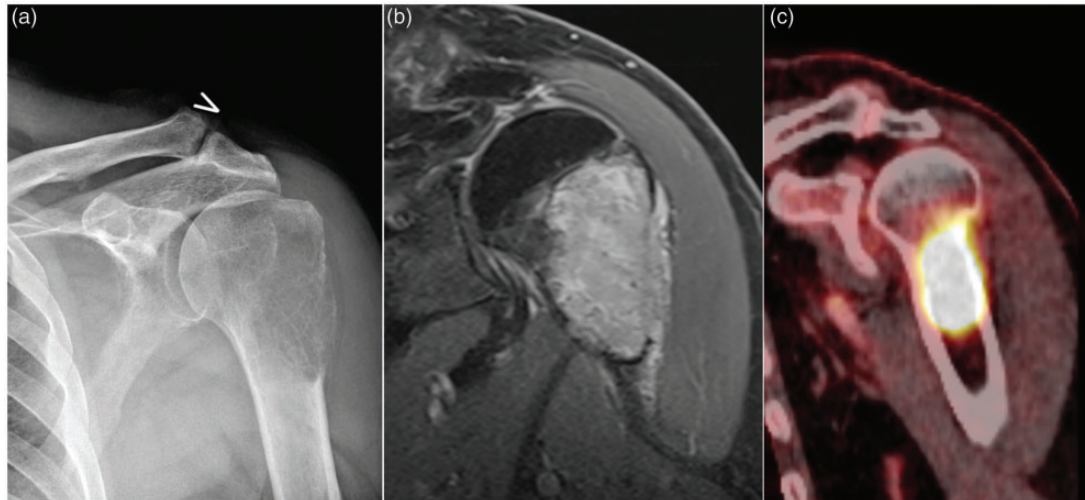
(a) X-ray examination of the left shoulder in frontal projection. (b) MRI of the left shoulder in the coronal view (T1-weighted fat saturated sequence with contrast). (c) PET-CT of the left shoulder in the coronal view.
